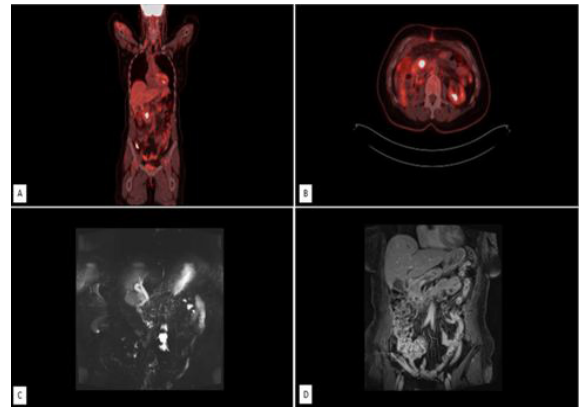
(A,B) Coronal and axial reconstructed images from PET/CT scan demonstrates increased metabolic activity at the head of the pancreas.
